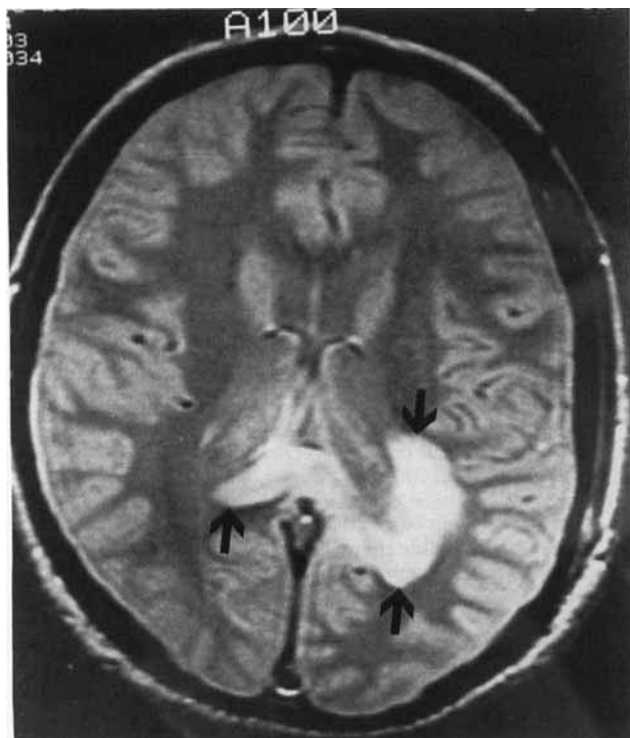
MRI of brain, Patient 1. A well-demarcated area of increased signal (arrows) on an axial proton density image involves both occipital lobes and the corpus callosum, completely sparing the cerebral cortex.
